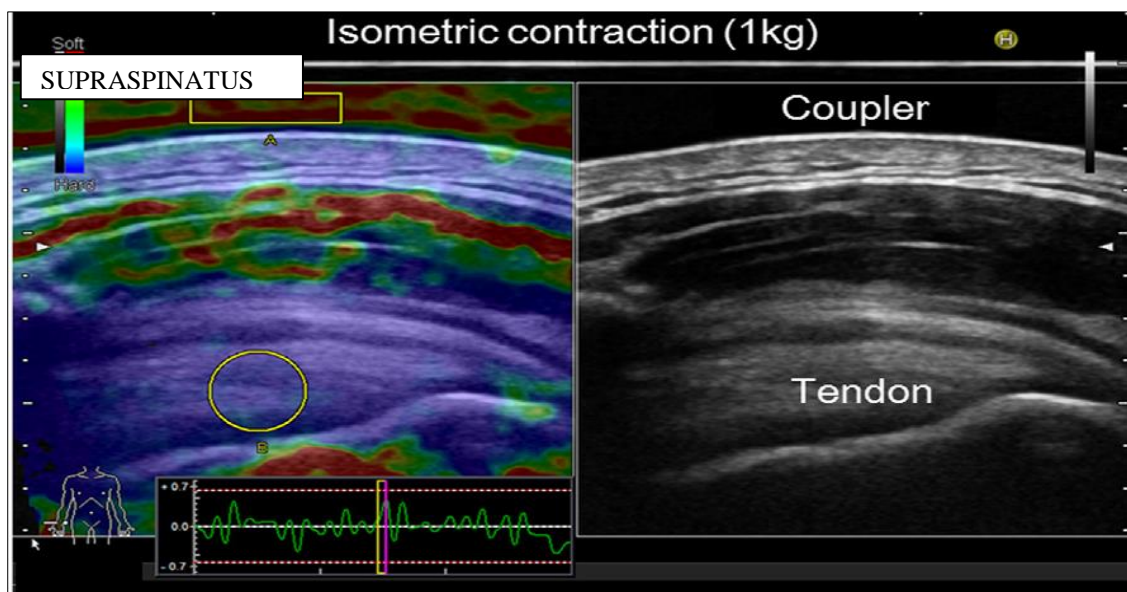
Strain ultrasound elastography of supraspinatus tendon. Region of interest (ROI) of supraspinatus is indicated by a yellow circle and ROI on acoustic gel is indicated by yellow rectangles. Blue represents hard elasticity. Adapted from Muraki *et al.* (2015: 125).
